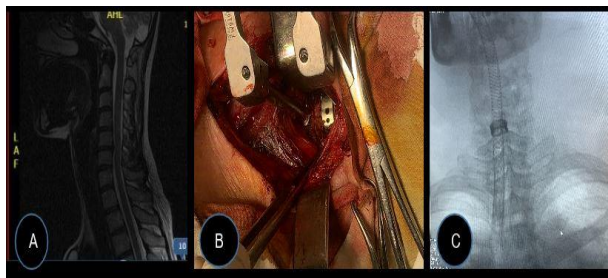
a) A 46-year-old female exhibits an MRI of the cervical spine revealing osteochondrosis and spondyloarthrosis. Median herniation b) C5-C6, resulting in compression of the C5 nerve root. Correction and cage implantation Microdiscectomy c) C5-C6, accompanied by anterior cervical fusion utilizing a C5-C6 cage.
